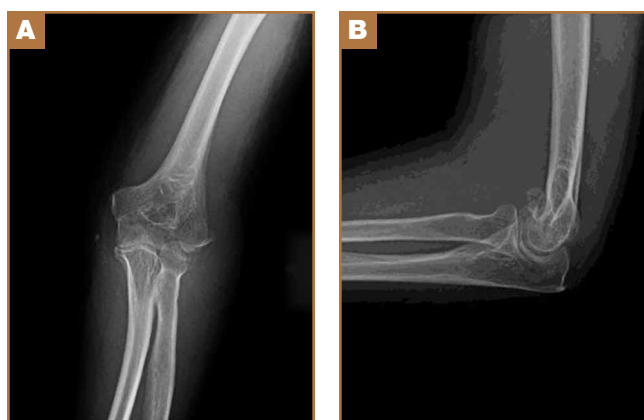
(A, B) Plain radiographs show multiplane fracture.
